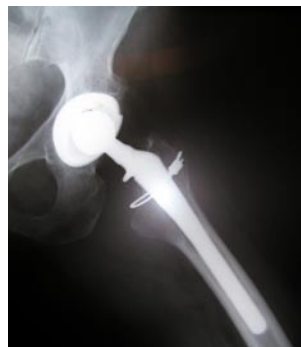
Preoperative and postoperative plain films of total hip arthroplasty in a post-polio patient.
